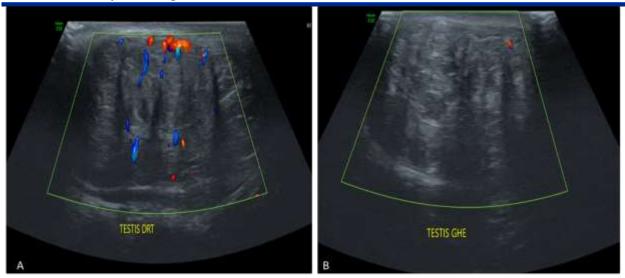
Ultrasound images of the right testis in the transverse (A) and sagittal (B) planes show an enlarged testicule, with diffuse, heterogeneous appearance.
